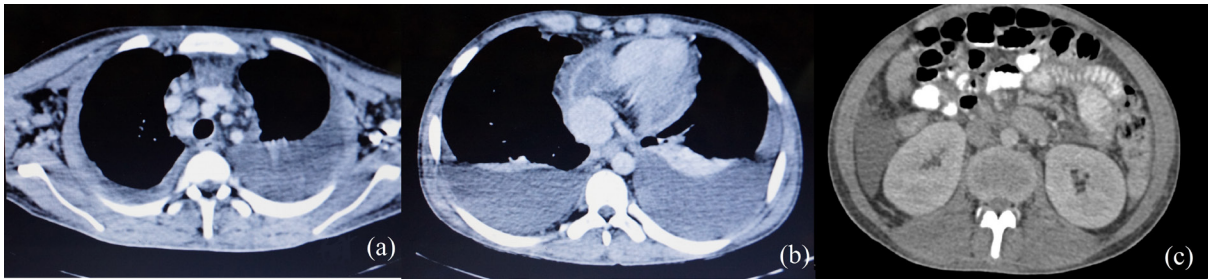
Chest CECT showing (a) multiple enlarged right paratracheal lymph nodes (b) bilateral pleural and pericardial effusion with enhancing pericardium, and (c) retroperitoneal lymph nodes. CECT, contrast enhanced computed tomography.
